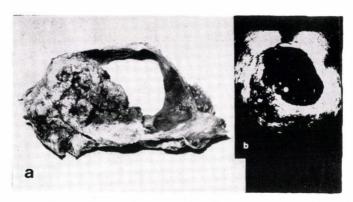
Extravesically infiltrating tumour invading and penetrating into the right lateral vesical wall. a. Overview scan (pT<sub>4a</sub>); b. intravesical ultrasonogram (U<sub>4</sub>)
